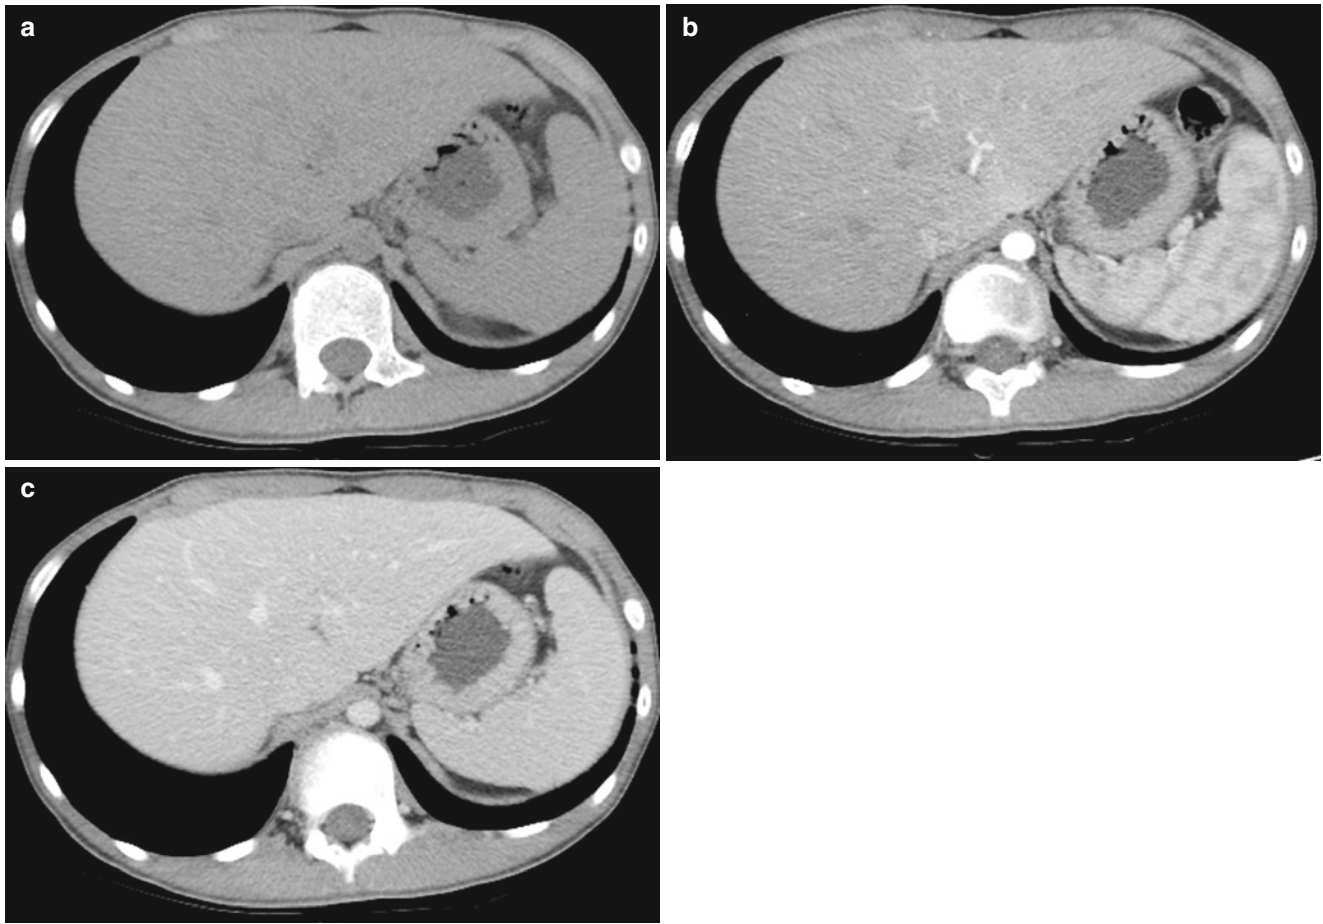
Normal spleen in a 12-year-old boy. (a–c) On abdominal CT, normal spleen shows iso-density with liver on pre-contrast image (a), heterogeneous, zebra-striped enhancement on arterial phase (b), and homogenous enhancement on delayed phase (c)
